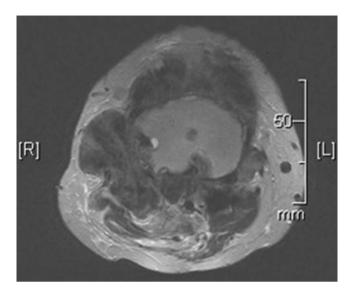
T1-weighted axial MRI image of a multiply recurrent tenosynovial giant cell tumor of the knee
